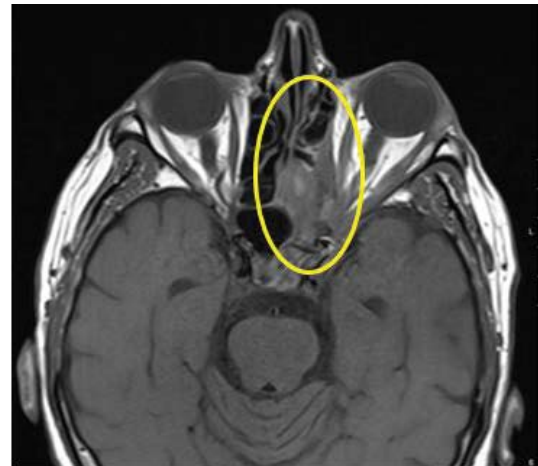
MRI Face and Orbits axial image: Yellow oval demonstrating acute and chronic left sphenoid sinusitis with secondary extension into the left orbit pterygopalantine fossa and left infrazygomatic masticator space.
